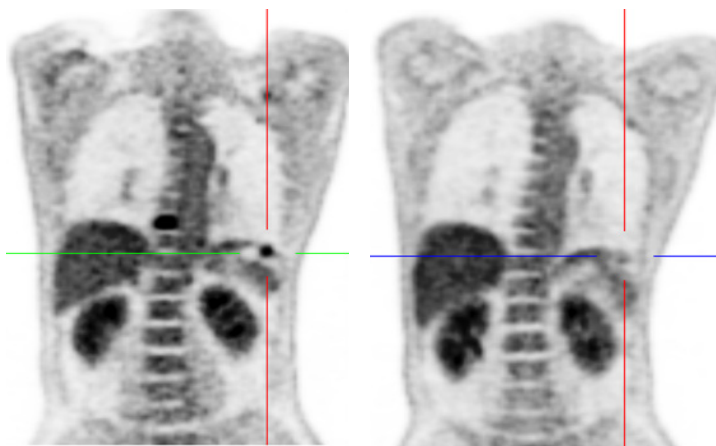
PET/CT treatment monitoring of a 60-year-old patient with left basal non-small lung carcinoma (NSCLC). The left panel: A coronal baseline PET image showing a 3.0 mm left FDG-avid lesion (SUV max: 7.56). The right panel: A coronal post-treatment PET image showing partial metabolic response of the left NSCLC lesion (SUV max: 3.17)
